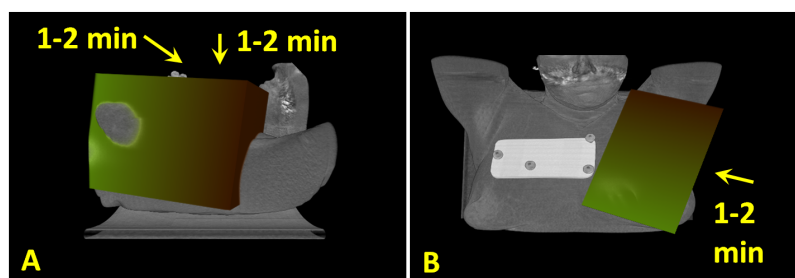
Scan protocol of freehand SPECT during pilot study. The protocol was divided into 1-2min acquisitions in the medial direction, 1-2min pointing in the dorsal direction, and 1-2 min in a craniodorsal direction.
